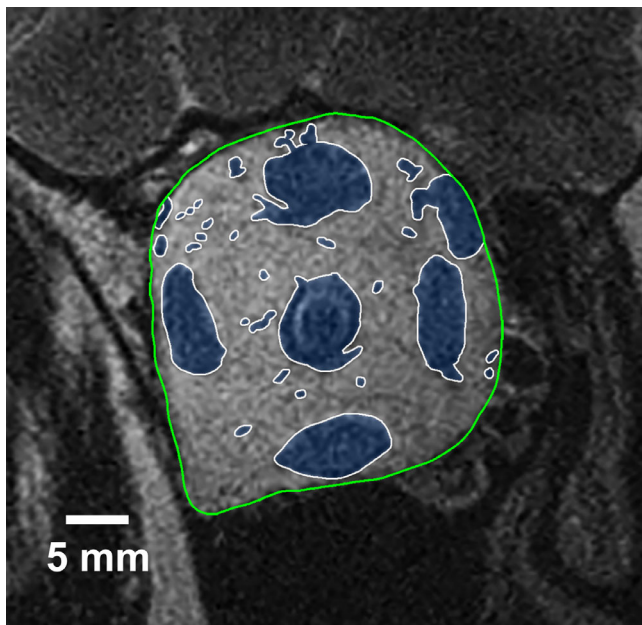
Quasicoronal MRI in the mid-portion of a representative right orbit, whose bony walls are outlined in green. Intraorbital structures including extraocular muscles, ON, and blood vessels, are outlined in white and shaded blue. Orbital fat represents the remaining orbital area excluding structures shaded in blue.
